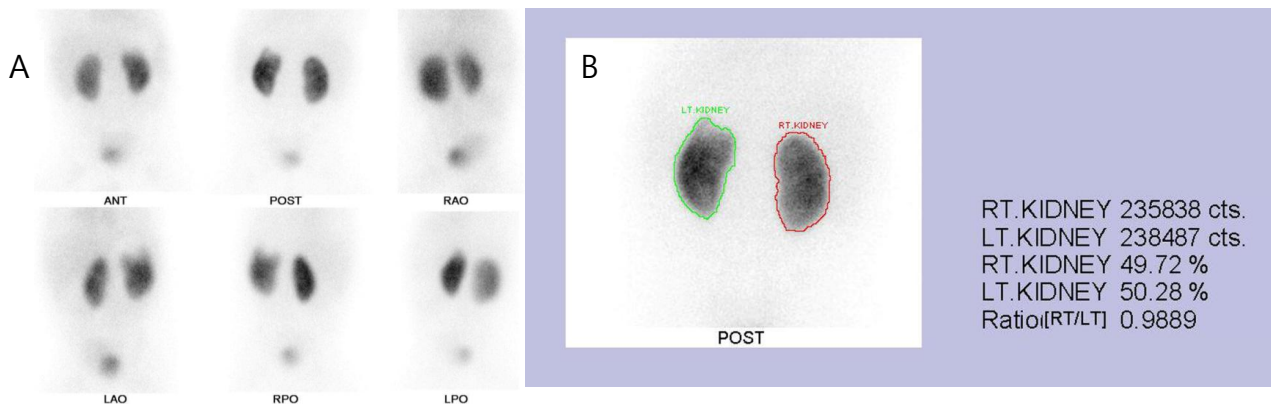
The cortical defect demonstrated in  $^{99m}\text{Tc}$ -DMSA planar renal scintigraphy. A) Focal cortical defect is noted in the upper pole of left kidney of 10 month-old male infant presented with acute febrile episode. B) The relative function is calculated from counts extracted in the region of interest (ROI) of each kidney.
